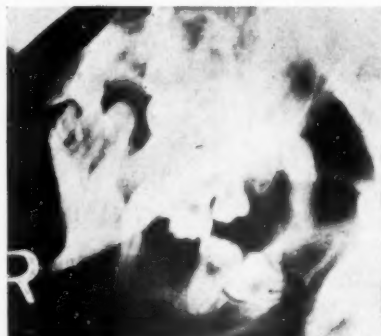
Radiograph of premature contact of 7/7 with 7/7 resulting in posterior displacement of the condyle on the same side.
